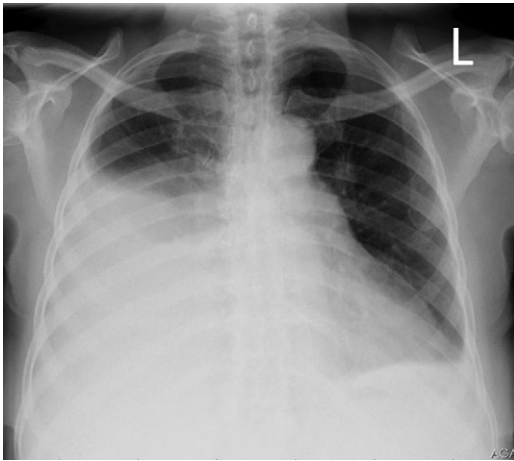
X-ray chest AP view showing large right pleural effusion with loss of right costo-phrenic and cardio-phrenic angle.
